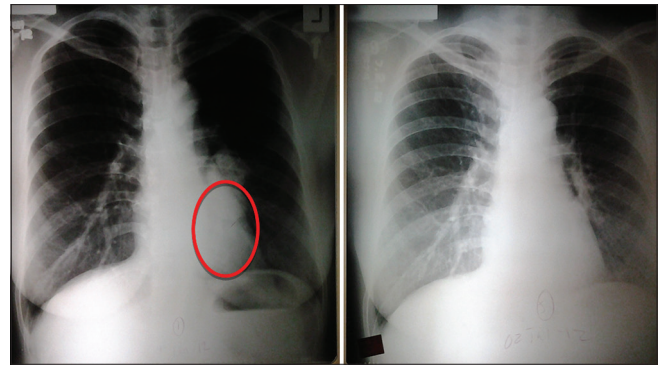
Chest radiograph of the Case 2 showing a 6.5 cm x 4.5 cm mass at the superior segment of the left lower lobe (left) and clearing of said mass (right) after chemotherapy
